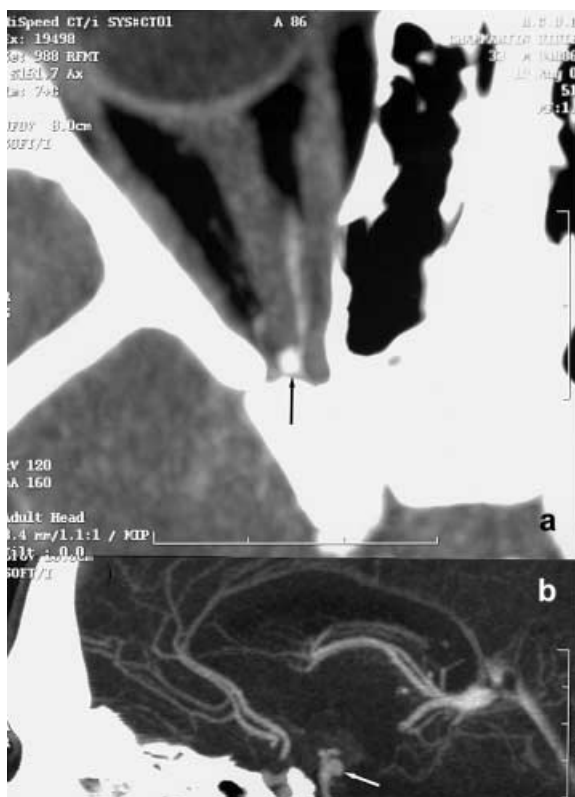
CT angiography shows a the small, unruptured aneurysm at the first bifurcation of the intraorbital part of the right ophthalmic artery, below the optic nerve (*black arrow*) and b the ruptured basilar tip aneurysm (*white arrow*) projecting posterosuperiorly
